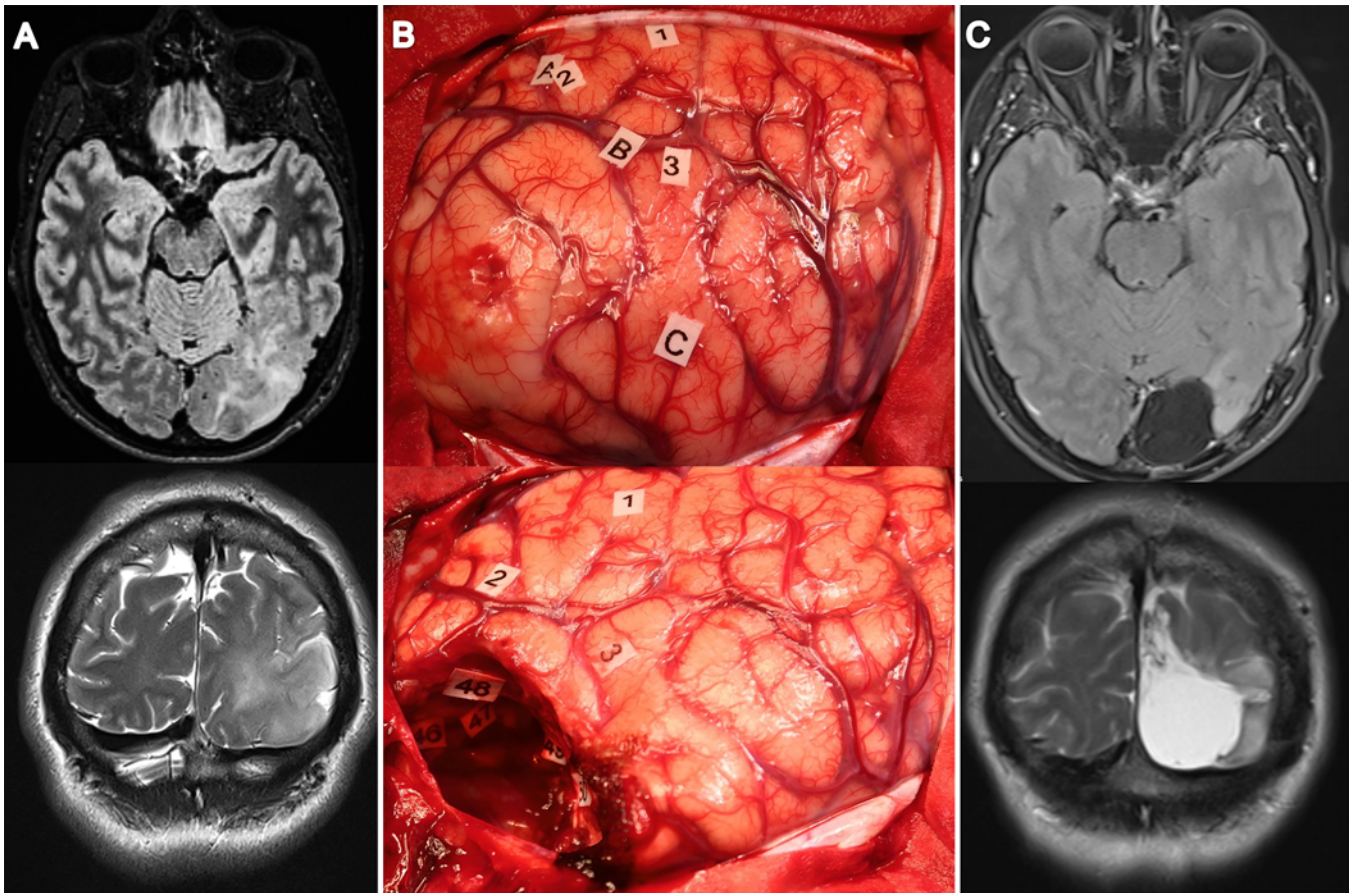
Case 3. Awake resection of a left occipital WHO grade 2 astrocytoma in a singer, guitarist, and composer. A: Preoperative axial FLAIR (*upper*) and coronal T2-weighted (*lower*) MR images showing a left occipital glioma. B: Intraoperative photographs obtained before (*upper*) and after (*lower*) connectome-based resection. C: Postoperative axial FLAIR-weighted (*upper*) and coronal T2-weighted (*lower*) MR images showing a subtotal resection.
